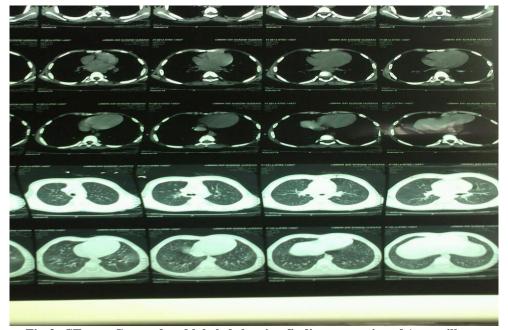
CT scan Cropped and labeled showing finding suggestive of Aspergilloma
